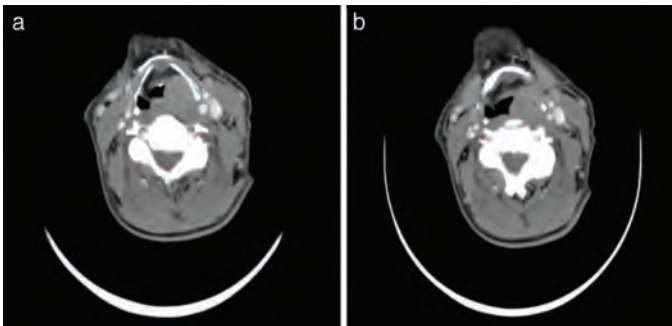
Computed tomography scanning of the mass
